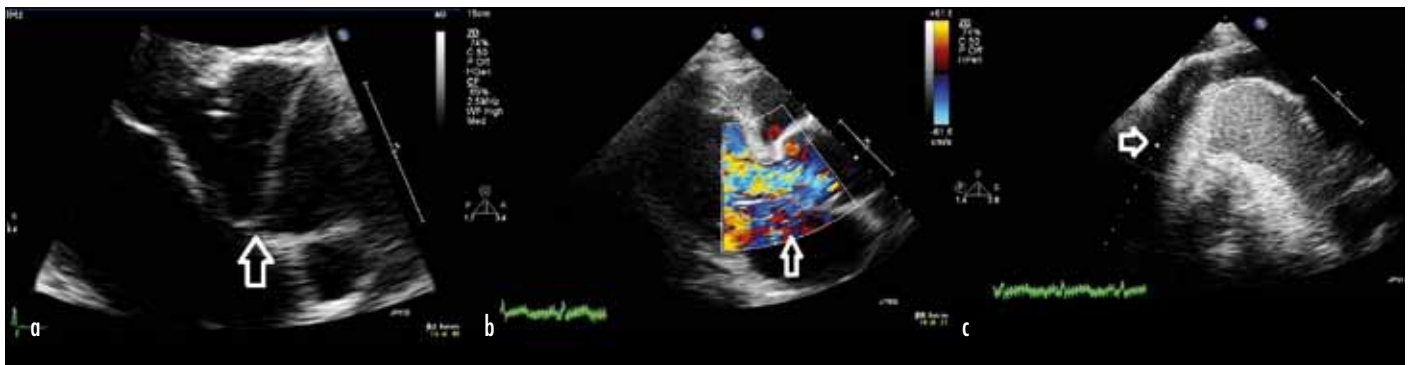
Transthoracic echocardiogram views. *a.* Dissection flap (indicated by arrow) is seen extending across the aortic root above the aortic valve. *b.* Turbulence is seen across the left ventricular outflow tract (arrow) in the parasternal long-axis view. *c.* Pleural effusion (arrow) as seen with echocardiogram.
